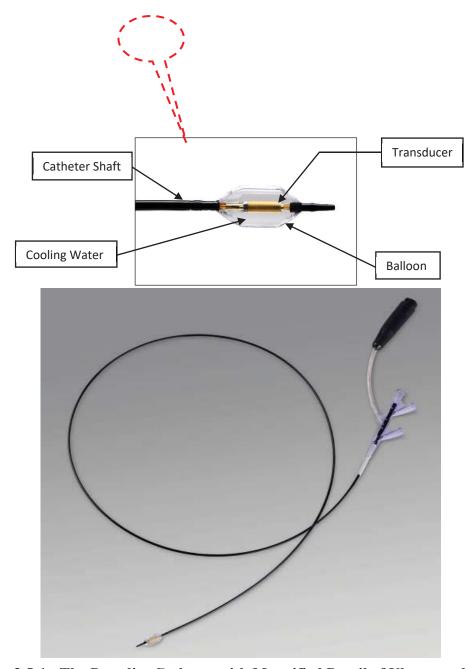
The Paradise Catheter with Magnified Detail of Ultrasound Source
